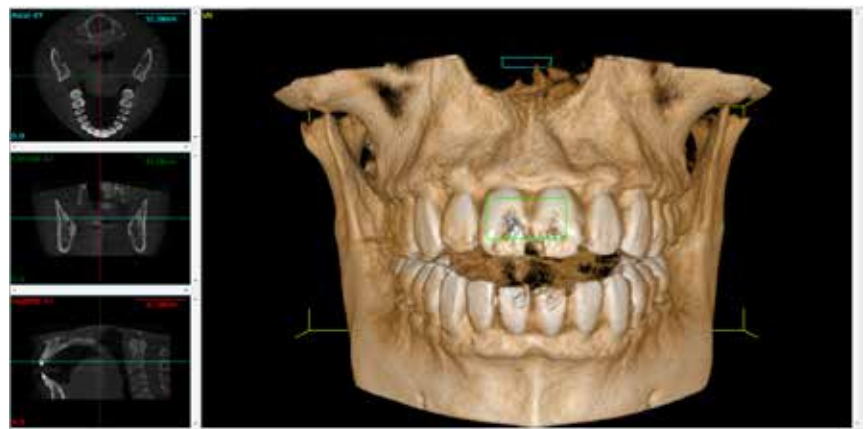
CBCT scan Wikimedia, Panda51, Cc-by-4.0
